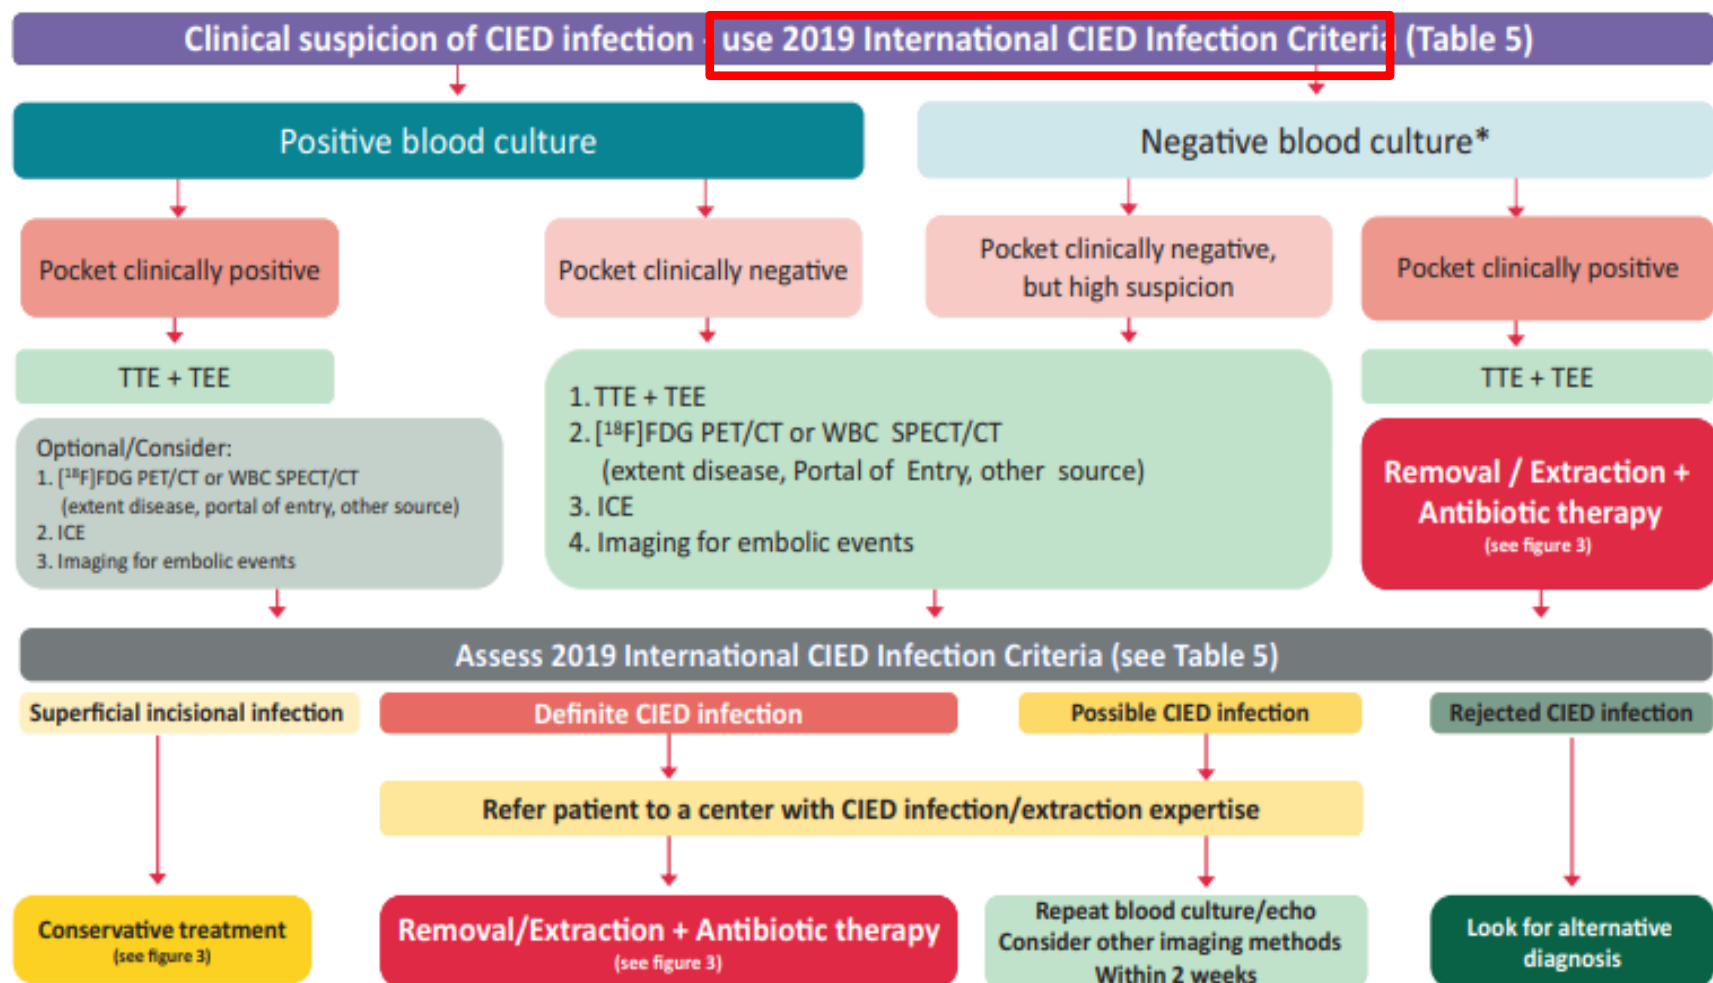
Diagnostic algorithm for diagnosis of suspected CIED infections. *, ensure sufficient number of blood cultures collected and absence of confounding antibiotic therapy prior to cultures. CIED, cardiac implantable electronic device; $[^{18}\text{F}]$ FDG PET/CT, fluorodeoxyglucose positron emission tomography—computed tomography; ICE, Intracardiac echocardiography; IE, infective endocarditis, TEE, transoesophageal echocardiography; TTE, transthoracic echocardiography; WBC SPECT/CT, white blood cell single-photon emission computed tomography—computed tomography.
